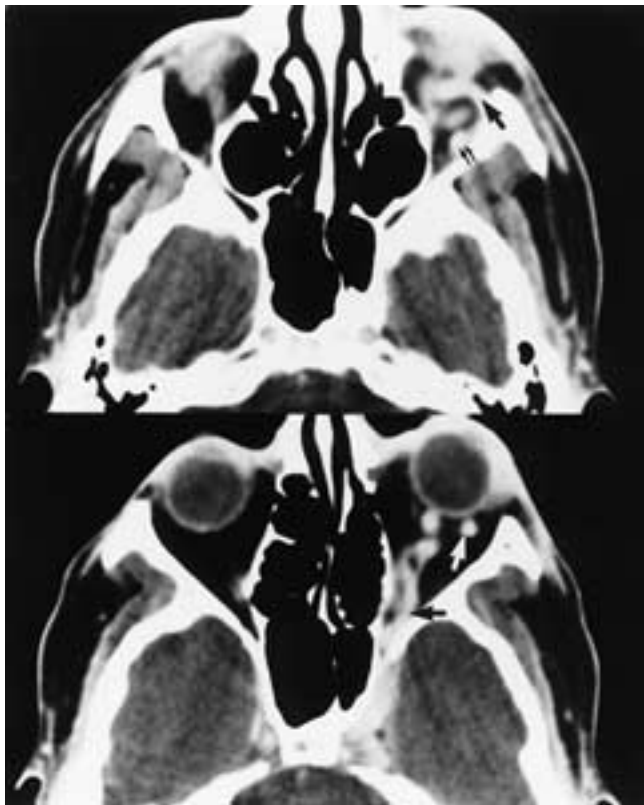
Carotid cavernous fistula. Enhanced axial CT scan shows enlarged intraorbital veins (*arrows*) and an enlarged left cavernous sinus.
